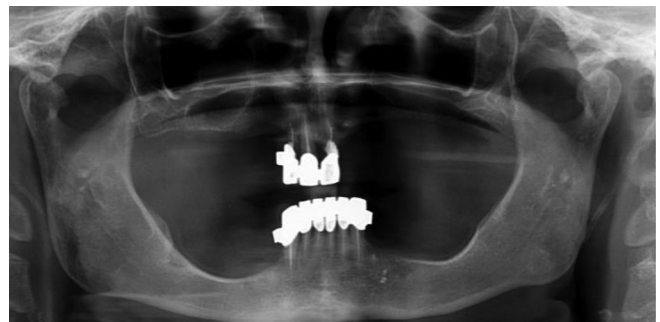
The panoramic radiograph revealed extensive sinus pneumatization and resorption of the mandibular posterior ridges.
